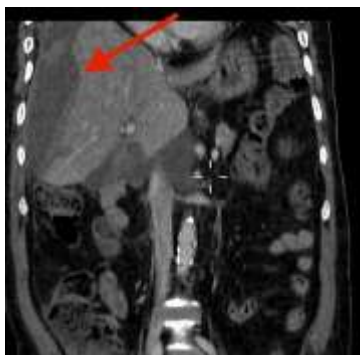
Coronal plane of CT abdomen showing a large subcapsular hematoma causing scalloping of hepatic margin as shown by red arrow.
